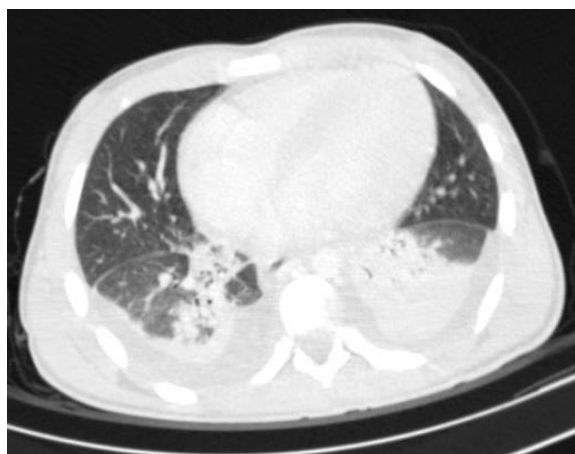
Axial chest CT scan parenchymal window shows areas of consolidation and adjacent ground-glass opacities adjacent to the basal abscesses
